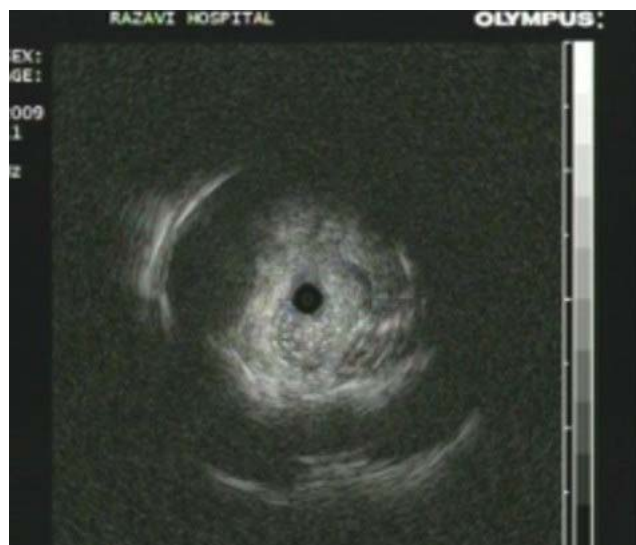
Endobronchial ultrasonography of an anthracofibrosis that protruded to the bronchial lumen. Note the hyperechoic nodule inside the lesion.
